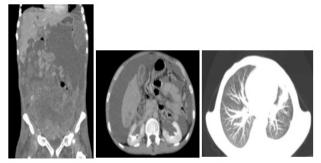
A: axial section of the abdominal and pelvic mass before CT B: Ureterohydronephrosis
